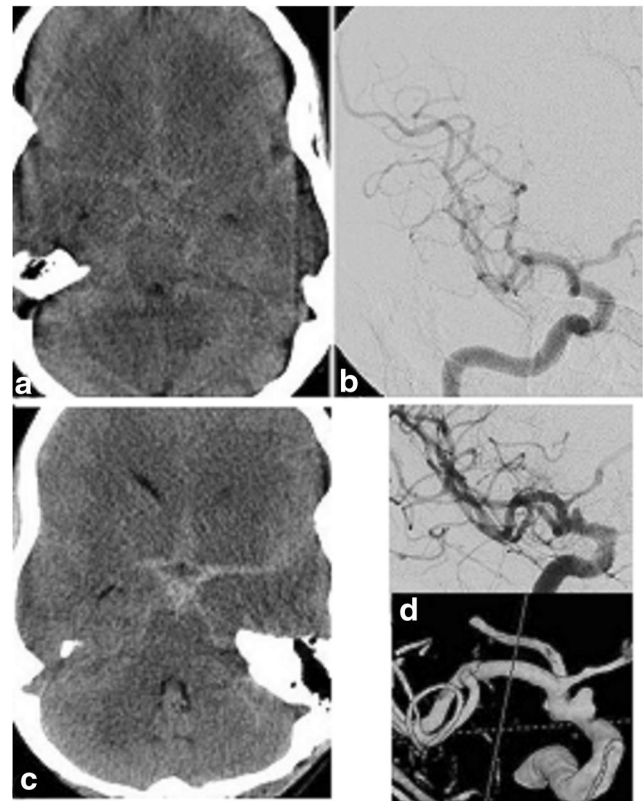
Case 3: A 40-year-old female with headache, neck stiffness and right eye pain. a Unenhanced CT head at presentation showing a diffuse pattern of hemorrhage. b DSA on day 2 shows no definite vascular abnormality. c Unenhanced CT head on day 8 post SAH shows further hemorrhage. d Repeat DSA and 3D model at day 10 post SAH shows a dissecting aneurysm of the supraclinoid ICA
